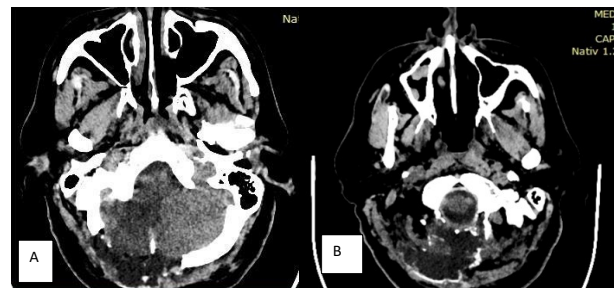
A. Postoperative CT Scan. Infratentorial Occipital craniectomy. Persistence of right cerebellar hemisphere and vermician hypodensity. B. Disappearance of tonsillar herniation.
